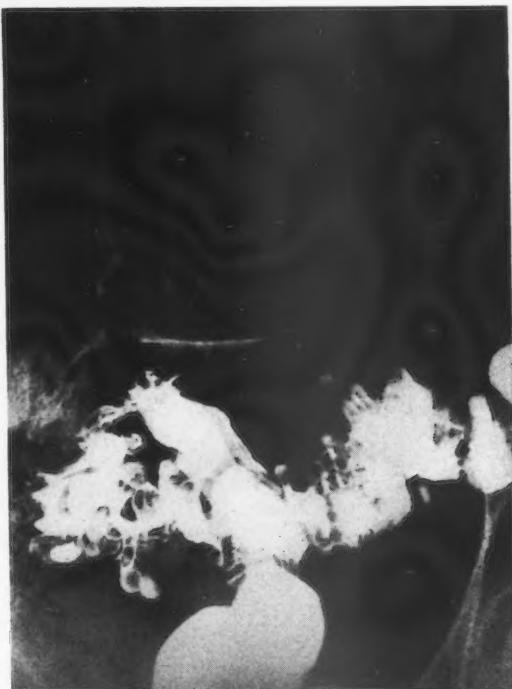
Roentgenological demonstration of multiple diverticulosis of large bowel. Suppurative diverticulitis is the most common cause of intestino-vesical fistula.
